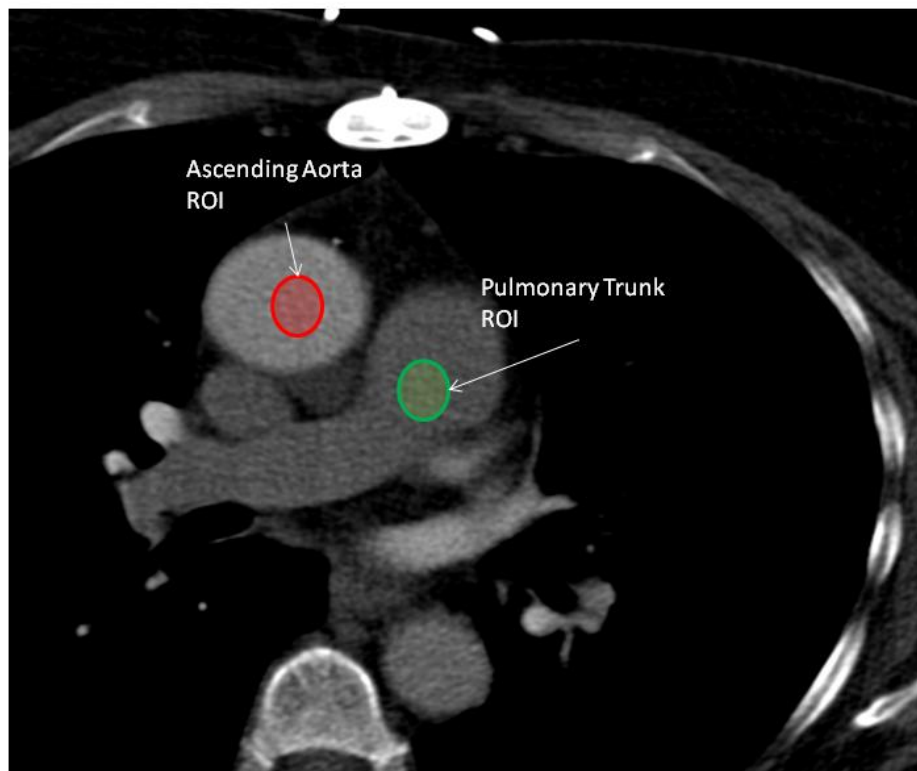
An axial CT image acquired from a test bolus scan procedure.
